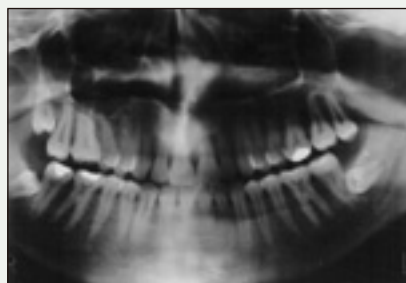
Orthopantomogram of horizontal bone-impacted left mandibular third molar in contact with the distal root of the second molar and not separated by a distoproximal bony septum.
